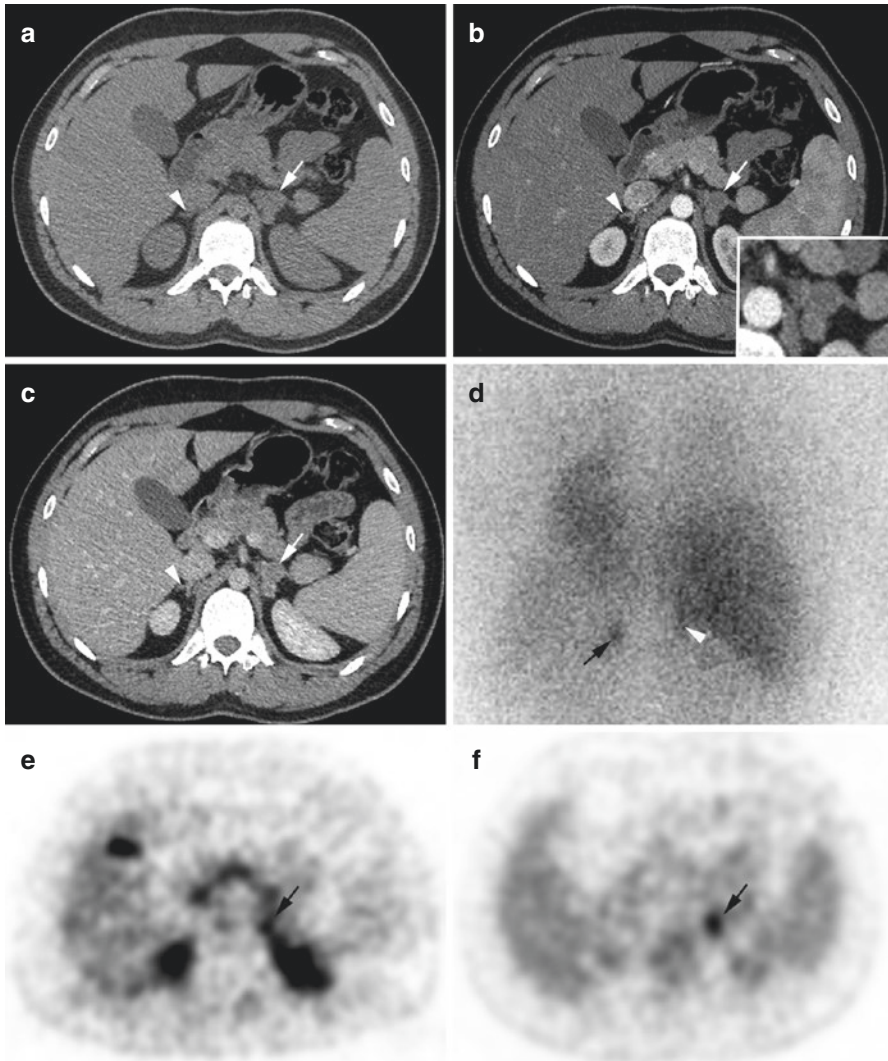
Unilateral MEN2A-related PHEO. Multiphasic adrenal CT (a–c), ^{18}F -FDOPA PET/CT, and (e) ^{18}F -FDG PET/CT (f) showed a single left PHEO (*arrow*) with normal contralateral gland (*arrowhead*), while ^{123}I -MIBG was falsely positive for the right adrenal gland. A total left adrenalectomy was performed with subsequent normalization of metanephrine. Pathological analysis found three PHEOs (20 mm for the largest tumor)
